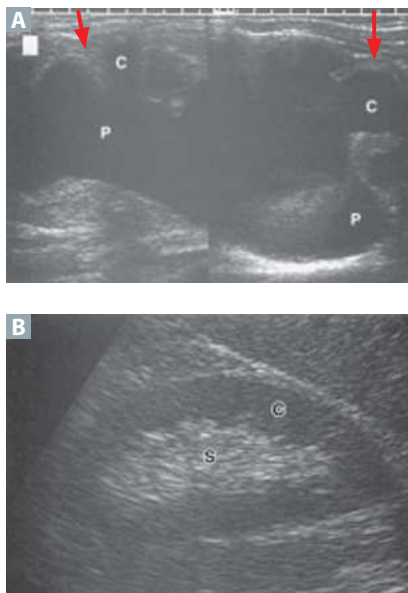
Hydronephrosis. (A) Ultrasound of a renal transplant shows severe hydronephrosis, with dilation of the renal pelvis (P) and the renal calyces (C). The overlying renal cortex is severely thinned (arrows). (B) Normal renal ultrasound for comparison. C, cortex; S, sinus fat. (Reproduced with permission from Tanagho EA, McAninch JW. *Smith's General Urology*, 17th ed. New York, NY: McGraw-Hill; 2008.)
